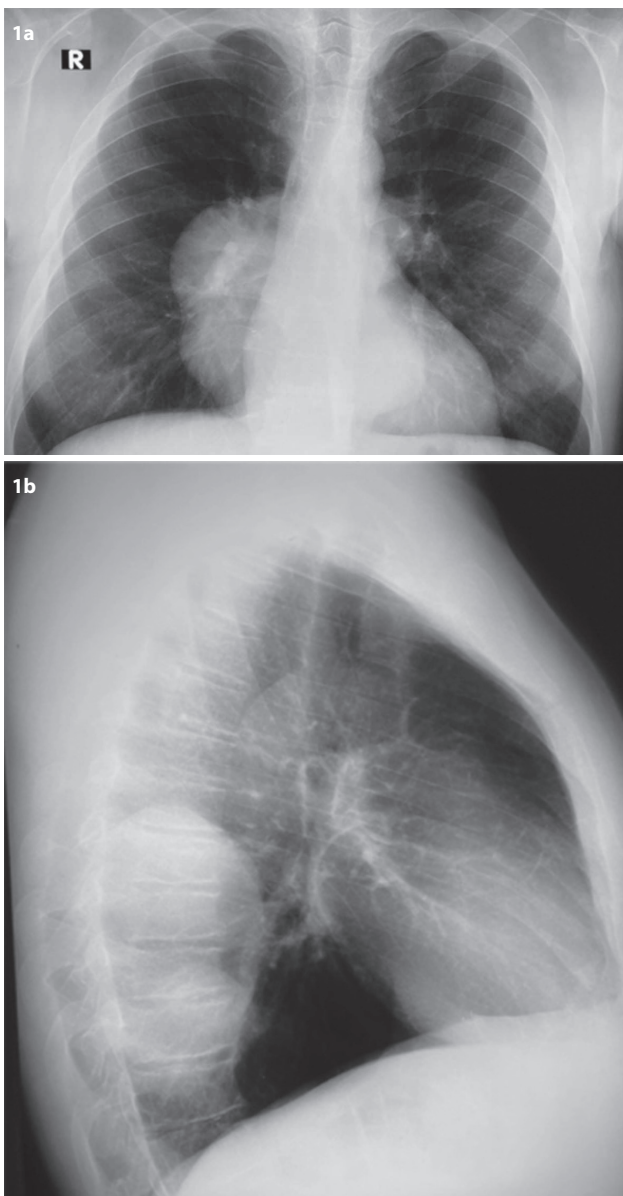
Chest X-ray, posteroanterior and lateral view, depicting opacities at thoracic levels T5–T8, adjacent to the vertebrae.
